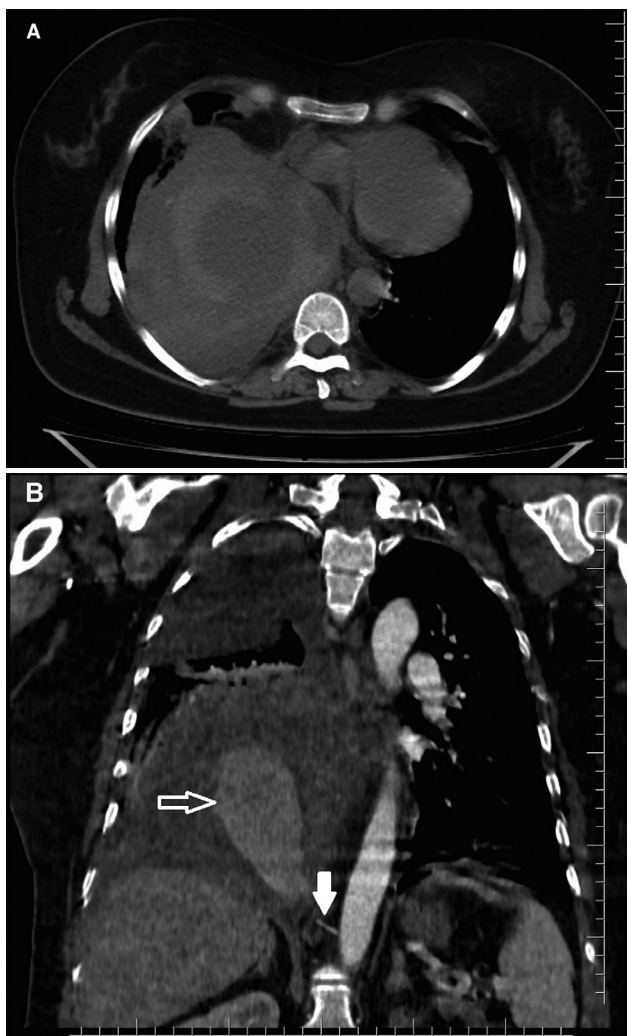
Non-contrast CT axial slice demonstrates a large hypodense lesion with a smooth contour in the lower region of the right lung and a ring of hyperdense thrombus peripherally A) Non-contrast computed tomography (CT) axial slice showing a large hypodense lesion with a smooth contour in the lower region of the right lung and a ring of hyperdense thrombus in the periphery of the lesion. B) Contrast-enhanced CT section of the coronal plane showing an aberrant left gastric artery (filled white arrow) arising from the right lateral wall of the aorta and a giant aneurysm (hollow white arrow) in the right inferior lung.
